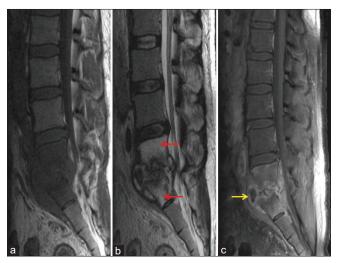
Magnetic resonance imaging after 8 weeks of baseline magnetic resonance imaging: (a) T1 sagittal, (b) T2 sagittal, (c) postcontrast images: The red arrows show an increase in marrow edema of L5 and S1 vertebral bodies as compared to previous scans [Figures 1 and 2]. A mild increase in sclerosis of L5 subjacent to L5-S1 disc is noted. The yellow arrow shows a minimal increase in the prevertebral collection; however, no significant change in the soft-tissue component as compared to previous scans [Figures 1 and 2]
